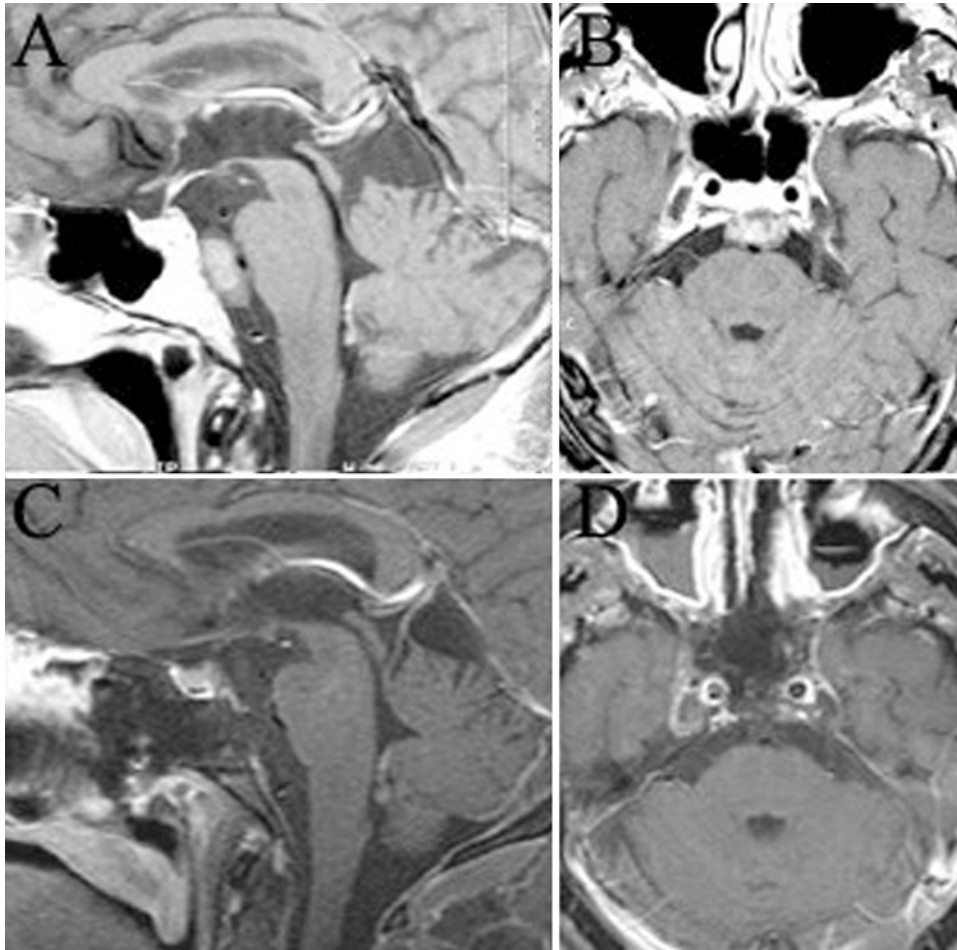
Enhanced sagittal and axial T1-weighted MR images. A and B: Preoperative images revealing a chordoma behind the midclivus. C and D: Postoperative images showing the clival bone window after complete removal of the lesion.
